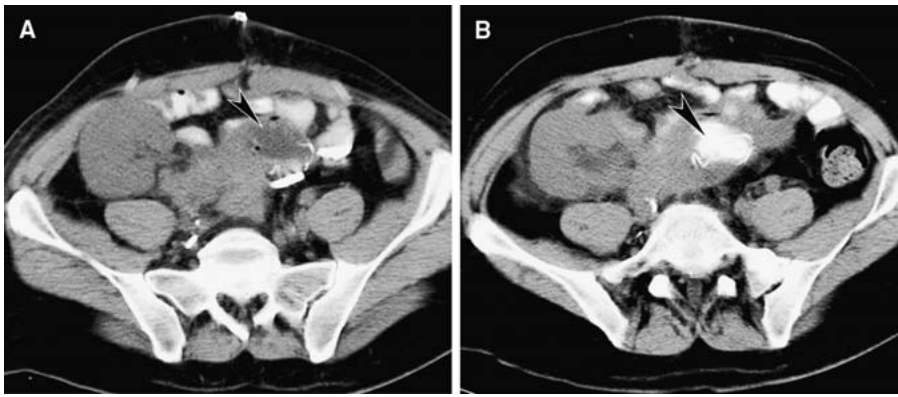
A Axial CT image without intravenous contrast in a 52-year-old male shows “fluid collection” (*arrowhead*) that did not opacify with oral contrast, contained gas bubbles, and was incorrectly interpreted as perigraft abscess. B Subsequent CT scan at the same level shows oral contrast within the structure that is surrounded by a ring of staples, confirming a normal donor duodenum (*arrowhead*).
